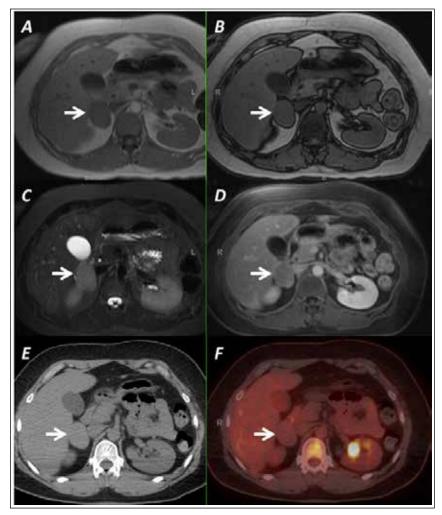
(A,B) Axial in and opposed phase T1-weighted gradient recalled echo imaging demonstrates lack of signal suppression, which excludes lipid-rich adenoma. (C,D) Axial fat-suppressed T2-weighted and contrast-enhanced magnetic resonance imaging demonstrate homogeneous, moderately T2-hyperintense, mildly enhancing soft tissue mass. (E) Axial unenhanced computed tomography imaging demonstrates soft tissue mass with internal attenuation value of 50 HU. (F) Positron emission tomography/computed tomography fusion image demonstrates low-level fluorodeoxyglucose uptake.
